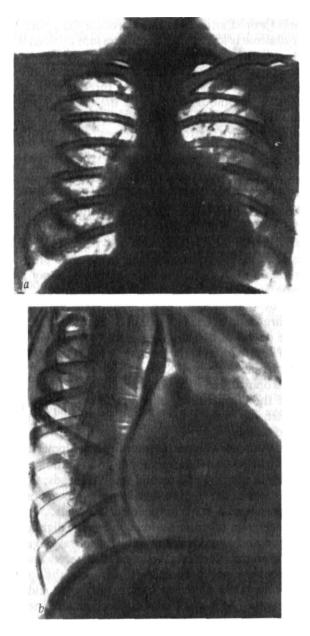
X-ray of a heart with mitral stenosis. *a*—mitral heart; *b*—deviation of the contrasted oesophagus by the small radius arc in the right anterior oblique position.
